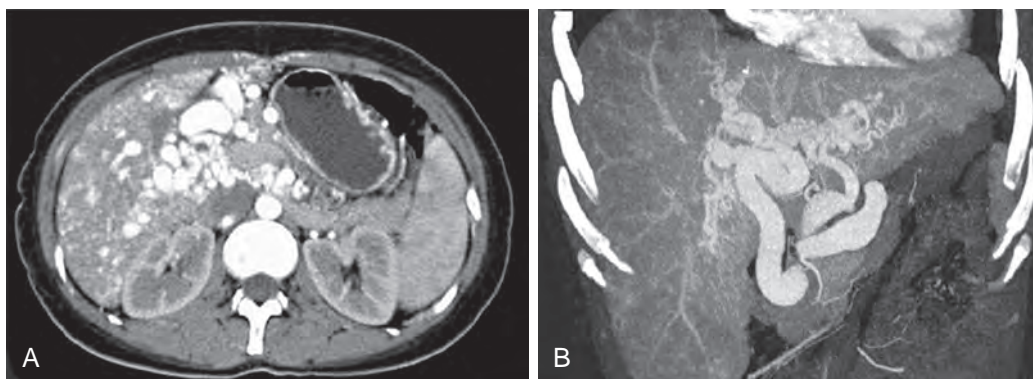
Osler-Weber-Rendu disease: CT features. A. Arterial phase axial CT image shows irregular and tortuous arteries in the liver parenchyma and porta hepatis. B. Coronal maximum intensity projection reconstructed image in arterial phase demonstrates tortuous and irregular arteries in liver and porta hepatis.
